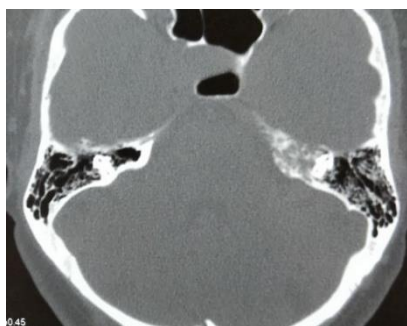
CT showing soft tissue lesion involving left petrous apex with bony wall erosion
